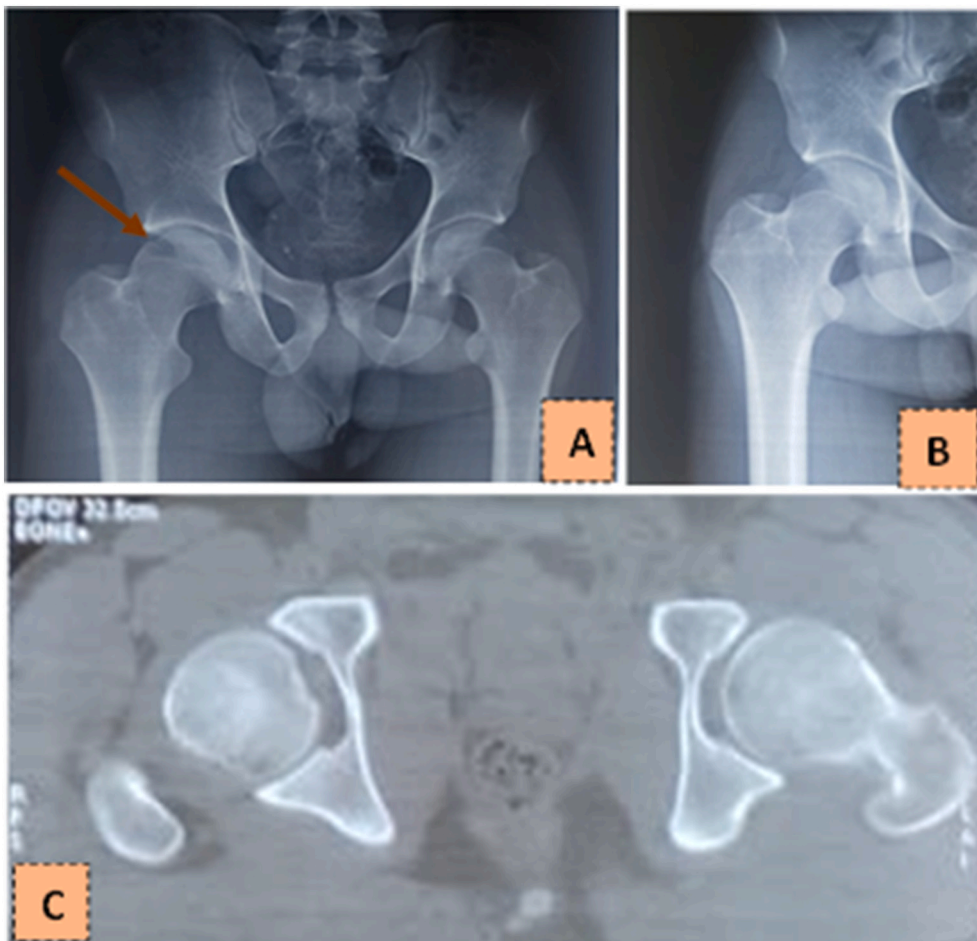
Case 2: A and B. Control AP radiograph of the pelvis showing the reduction and the presence of a notch in the posterosuperior part of the femoral head. C. CT scan on transverse sections: good head-acetabular congruence and absence of intra-articular fragment.
